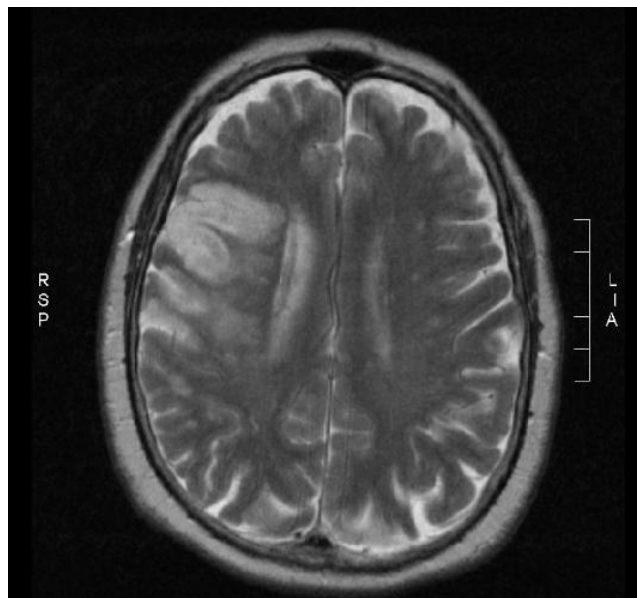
An axial slice through the patient's T2-weighted brain MRI. This demonstrates an acute infarct in the territory of the right middle cerebral artery involving the frontal, temporal and parietal lobes.
